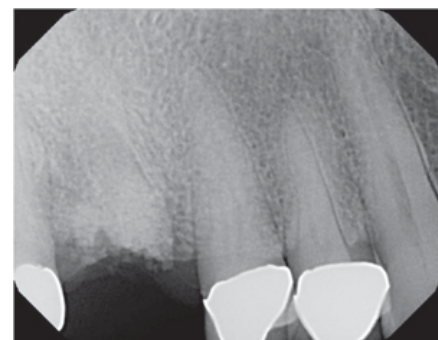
Post operative radiograph of the graft material in place.
